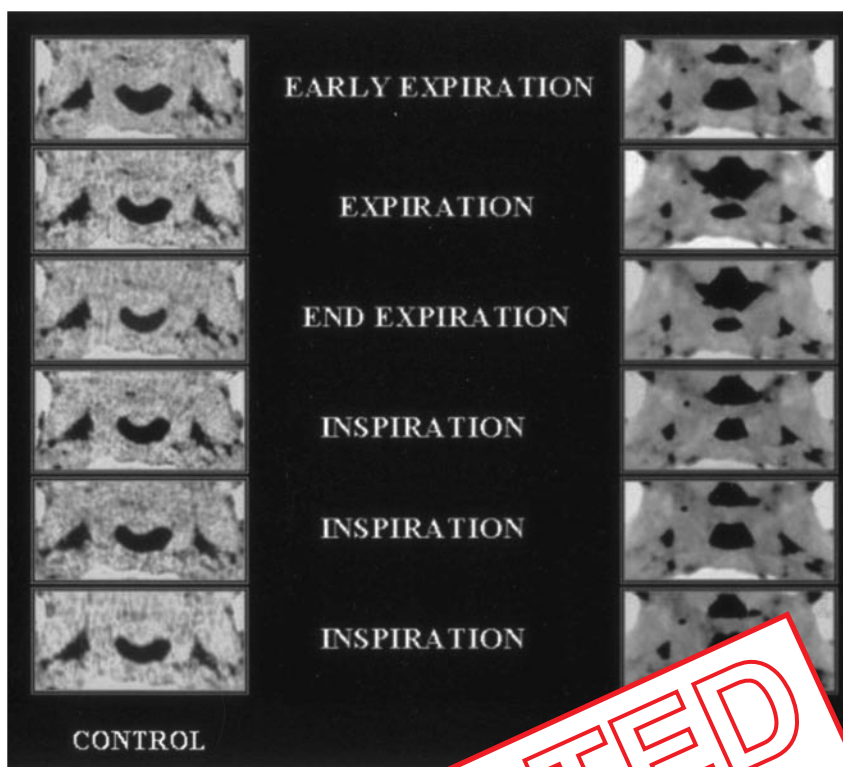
Axial cine CT scans show dynamic oropharyngeal airway changes in snoring patients and healthy control subjects.
